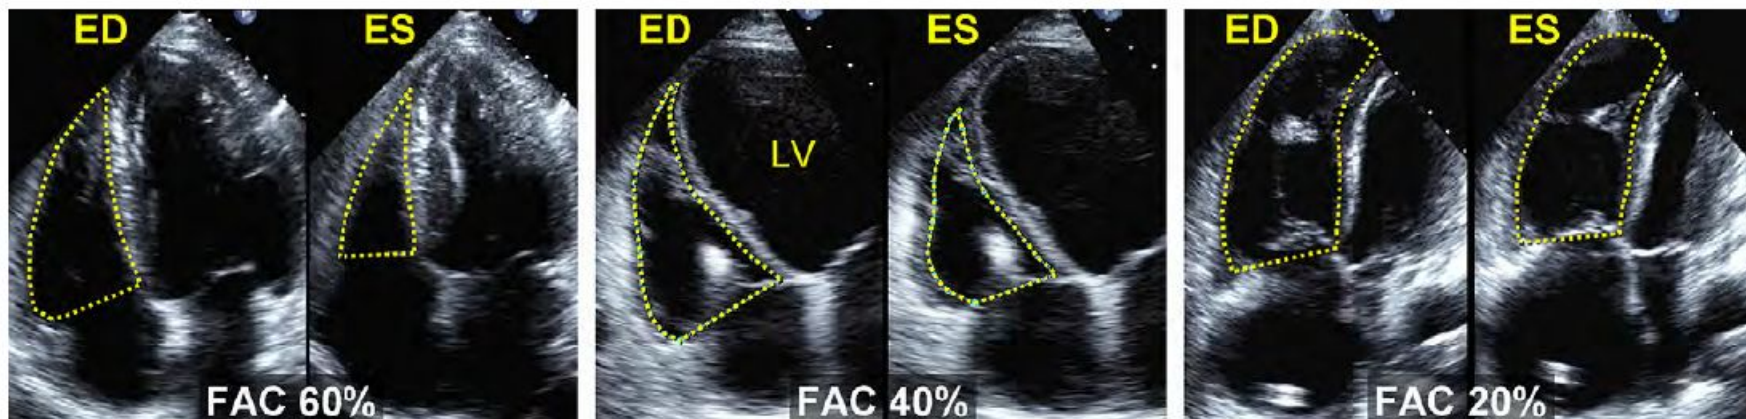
Examples of right ventricular fractional area change (FAC). Percentage $FAC = 100 \times \frac{\text{end-diastolic area (AreaED)} - \text{end-systolic area (Area ES)}}{\text{end-diastolic area}}$. The endocardial border is traced in apical 4-chamber (A4C) views from the tricuspid annulus along the free wall to the apex, then back to the annulus, along the interventricular septum at end-diastole (ED) and end-systole (ES). Trabeculation, tricuspid leaflets, and chords are included in the chamber. (Left) Normal subject, FAC 60%. (Middle) Moderately dilated right ventricle (RV), FAC 40%, and a markedly dilated left ventricle (LV). (Right) Dilated RV, FAC 20%, and the LV is foreshortened as a result of optimizing the view for the right ventricular chamber.
